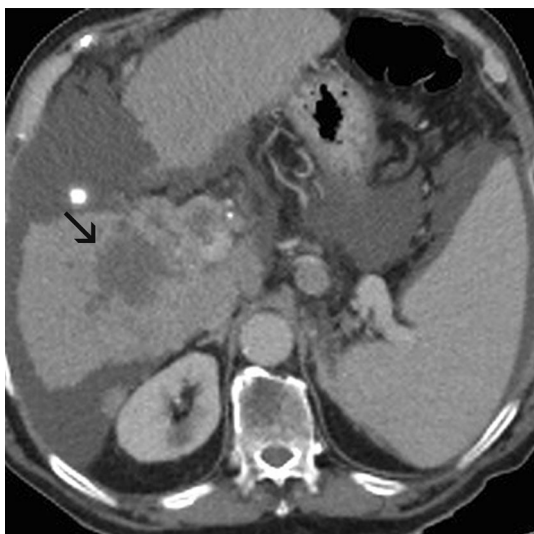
A 69-year-old male, known to have liver cirrhosis, referred for targeted biopsy of a hepatic lesion (*arrow*). Review of recent CT images showed moderate amount of ascites. Persistent ascites was confirmed by ultrasound and the patient was scheduled for percutaneous ascites drainage prior to the biopsy to decrease the risk of uncontrolled bleeding
